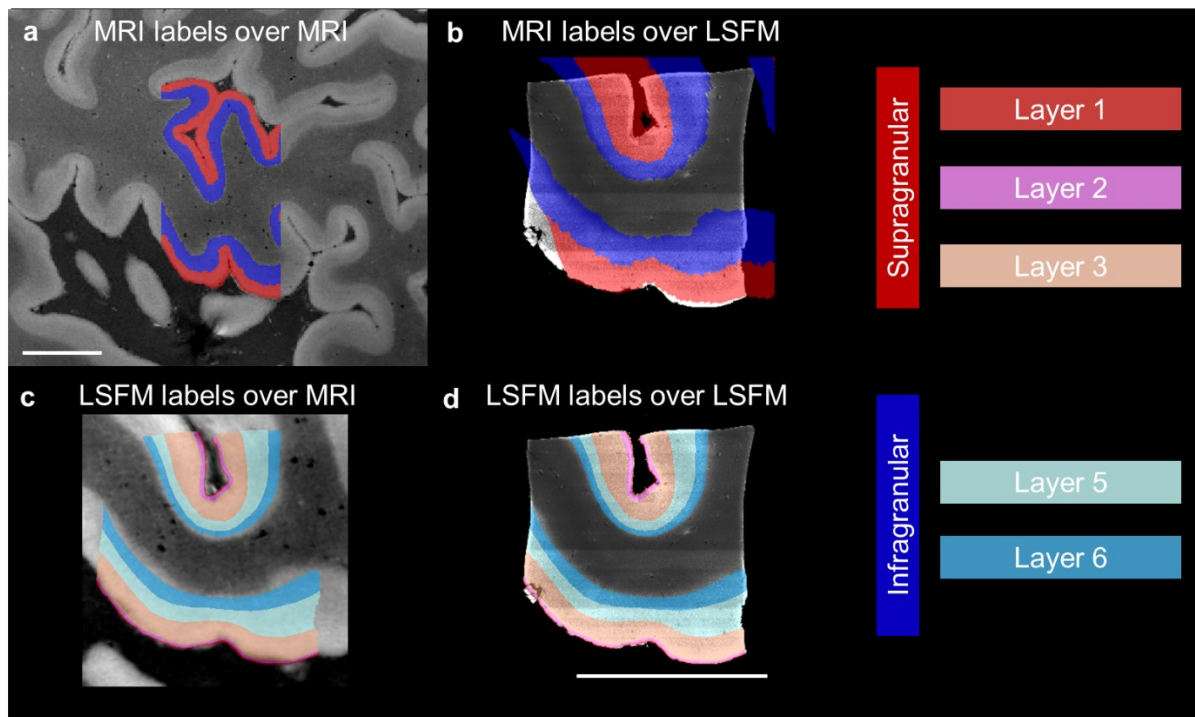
Overlap of Infragranular and supragranular laminar labels derived from MRI and LSFM after coregistration. a) MRI overlaid with the manually labeled infra- and supragranular layers. b) LSFM overlaid with the same MRI-derived labels after registration. c) MRI warped in LSFM space overlaid with LSFM-derived laminar labels. d) LSFM overlaid with manually labeled cortical layers. There is no internal granular layer 4 in Broca's area. Scale bars = 1cm.
